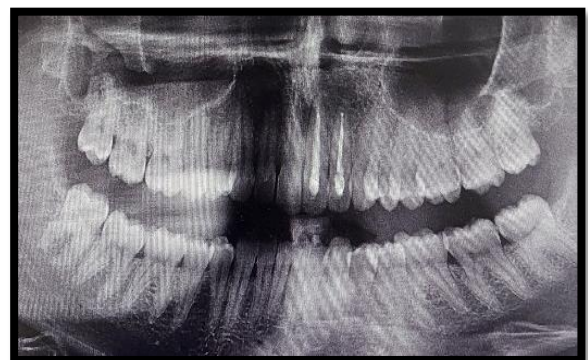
Radiographic 6 months follow up : reossification of the lesion
